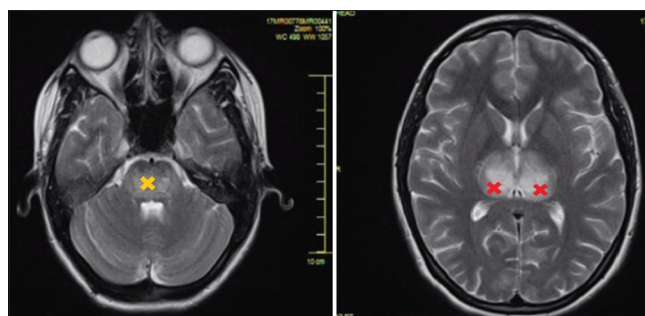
Axial T2-weighted magnetic resonance imaging showing bilateral thalamic (right image) and pontine hyperintensities (left image) with some blooming in susceptibility-weighted imaging suggestive of hemorrhagic encephalitis
